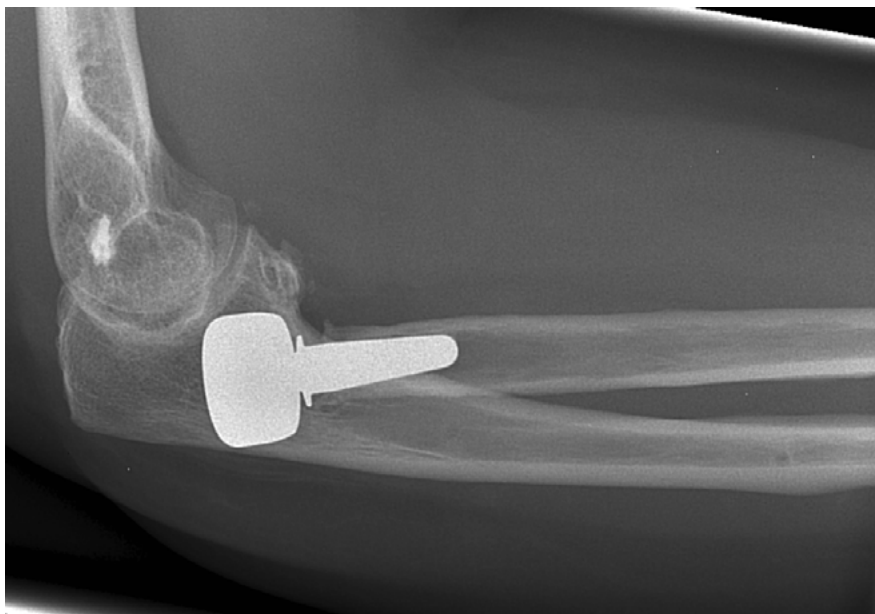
lateral radiograph of case 29 show the subluxed position of the press-fit bipolar radial head prosthesis onto the capitellum. There is distinctive proximal osteolysis around the implant.
